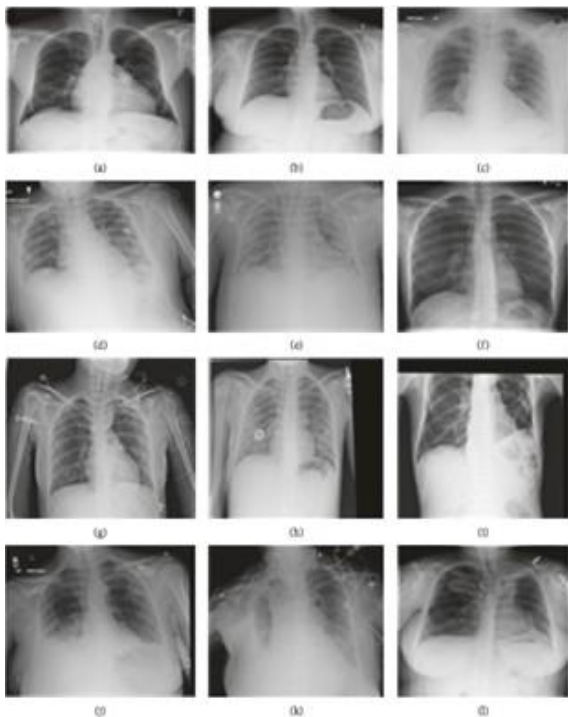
Samples of chest x-ray images.
